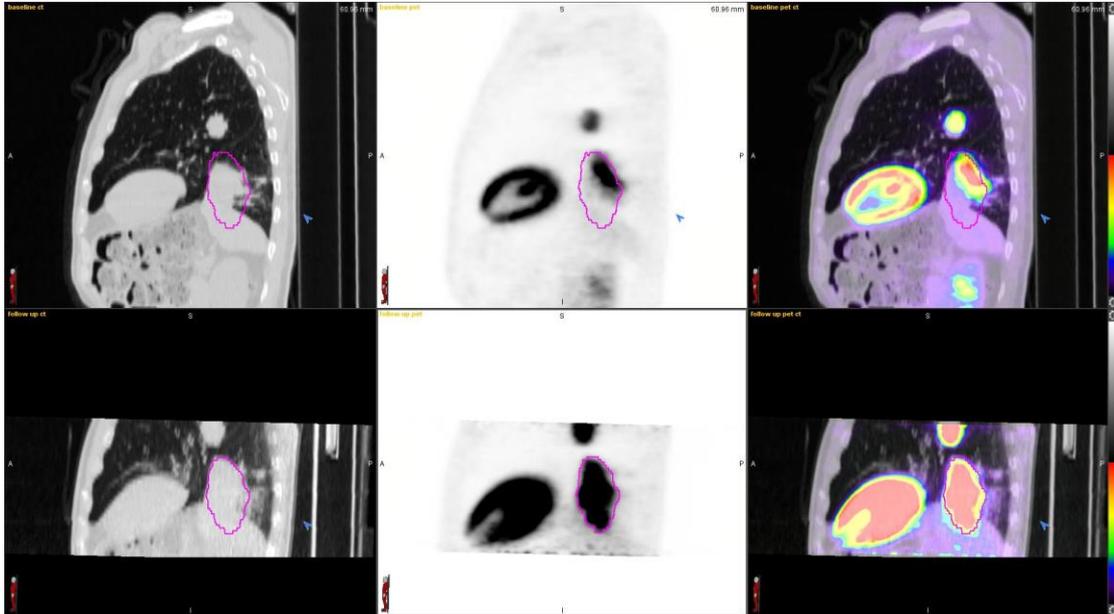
3D-CT versus 4D-CT MIP
